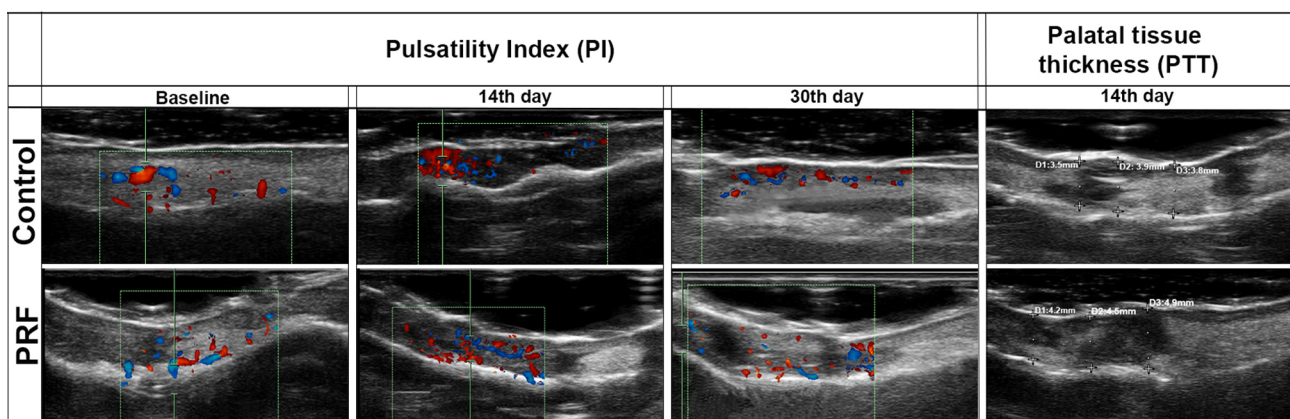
Blood flow was displayed in the wound area using pulsed-wave Doppler modes at baseline, 14<sup>th</sup>, and 30<sup>th</sup> days and palatal tissue thickness was measured using the B-mode from several points on the 14<sup>th</sup> day
